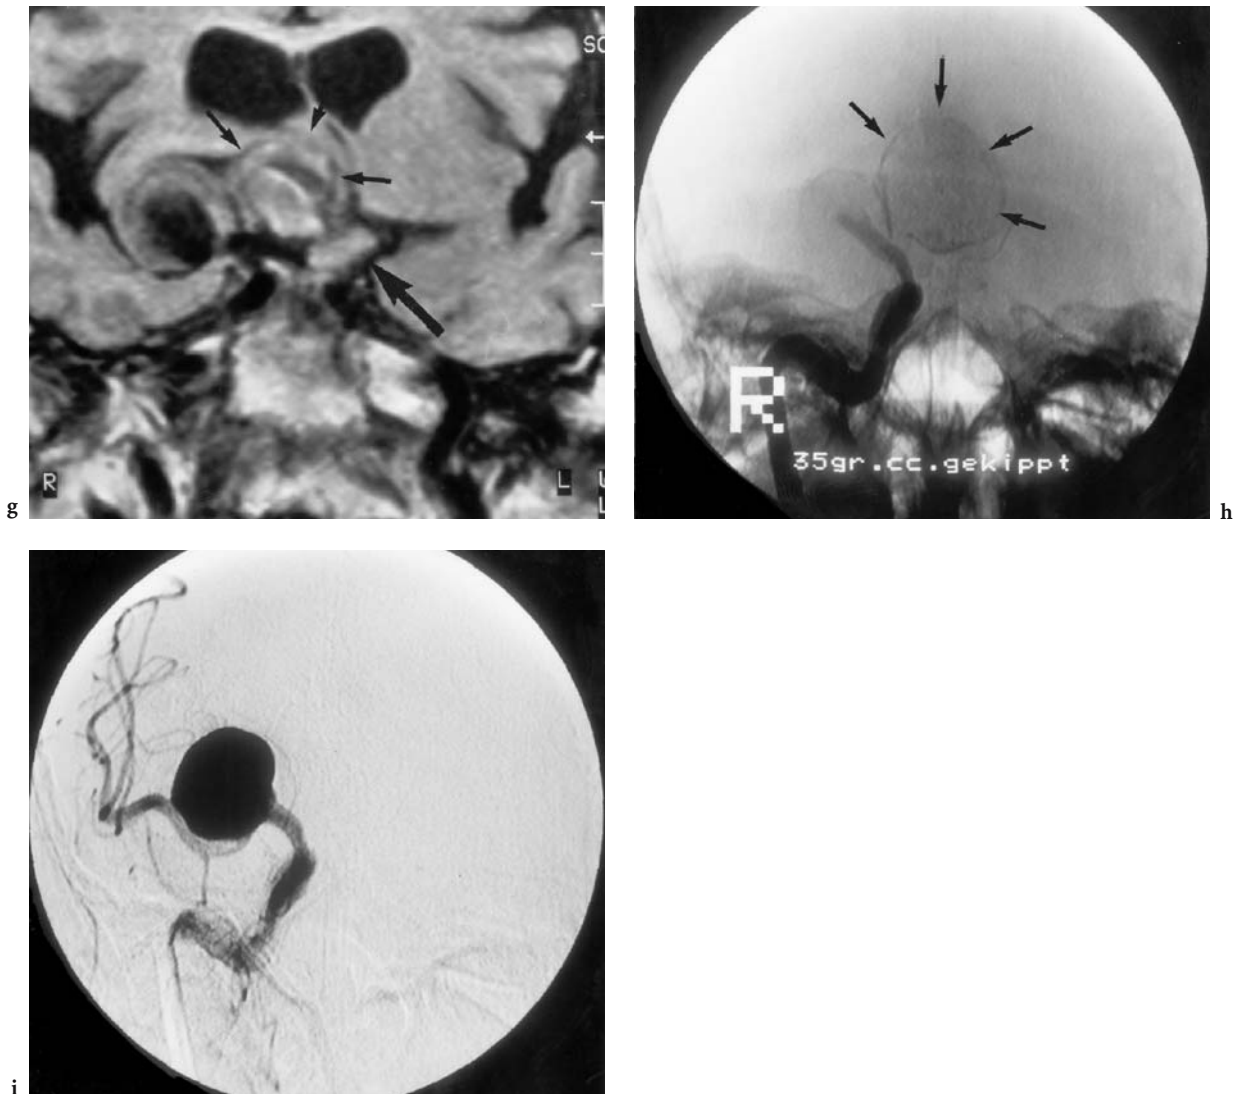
A 66-year-old woman with pressure sensation behind the right eye and slowly progressing visual deficit (bilateral 0.8), presenting with incomplete N III paresis of the right eye. Diagnosis: partly thrombosed (butterfly-shaped) aneurysm of the right ICA bifurcation. CT: a Axial native view at the suprasellar region, showing a ring-shaped coarse calcification in the right paramedian region of the basal ganglia and thalamus. MRI: b Axial T2-weighted view of the suprasellar region showing an irregular flow void lateral to the ICA bifurcation, as well as a hypointense structure in the interpeduncular cistern. c Corresponding (enlarged) T1-weighted view demonstrating the flow void of the open area of the aneurysm, in addition to an onion-shaped (older) thrombosed part frontal to the aneurysm (*small arrows*). The slightly hyperintense, sharply defined lesion in the midline compresses the chiasm (*arrow*) as well as the left cerebral peduncle, and represents another thrombosed area of the aneurysm. d Midsagittal T1-weighted native view, showing depression and dislocation superior to the chiasm (*arrow*) by the completely thrombosed and calcified suprasellar area of the aneurysm, extending to Monro's foramen (*white star*). DSA: e Lateral non-subtracted view (early arterial phase) documenting the size of the calcification (*small arrows*, compare to a) as well as the inflow zone (*large arrow*) of the open area, representing a prolongation of the horizontal course of the distal ICA. f Late arterial phase, documenting first the very slow flow of the generally dilated arteries and demonstrating second the size of the open, not thrombosed area of the aneurysm. Note the lack of opacification of the ipsilateral ACA. g Coronal T1-weighted native MRI documenting the butterfly shape of the lesion: Note the (hypointense) flow void of the open aneurysm in the extension of the right ICA, surrounded by the onion-shaped thrombotic area (compare with c) and the completely thrombosed medial part with a distinct calcified wall (*small arrows*), depressing the basal ganglia and thalamus (compare with a); the *large arrow* indicates the distal part of the left ICA. DSA: h Early arterial phase in frontal projection (Towne), corresponding to e with labeled calcification (non-subtracted view). i Arterial phase (corresponding to f, g) where the entire open area is demonstrated as well as the origin of the aneurysm at the ICA bifurcation with location of the right M1 segment below. Note the lack of opacification of the ipsilateral ACA, which may be due to both compression and (by the thrombosed part) minor antegrade flow
